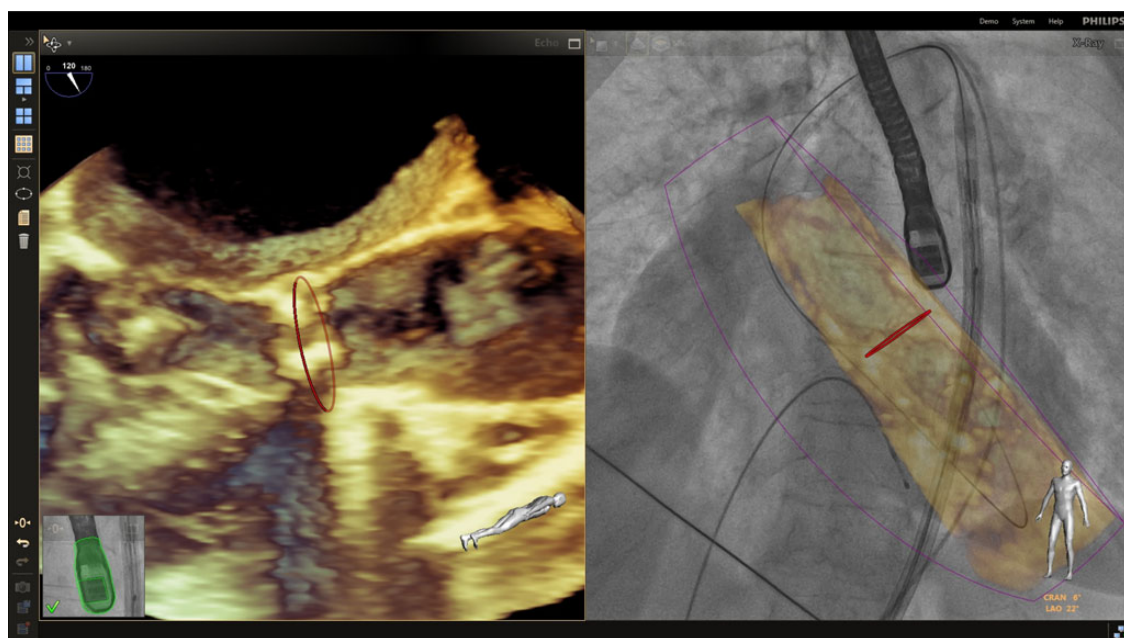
EchoNavigator screen image showing a 3D echocardiography image of the aortic valve and a fusion image of echocardiography in 3D and fluoroscopy of the aortic valve during a TAVR procedure.
